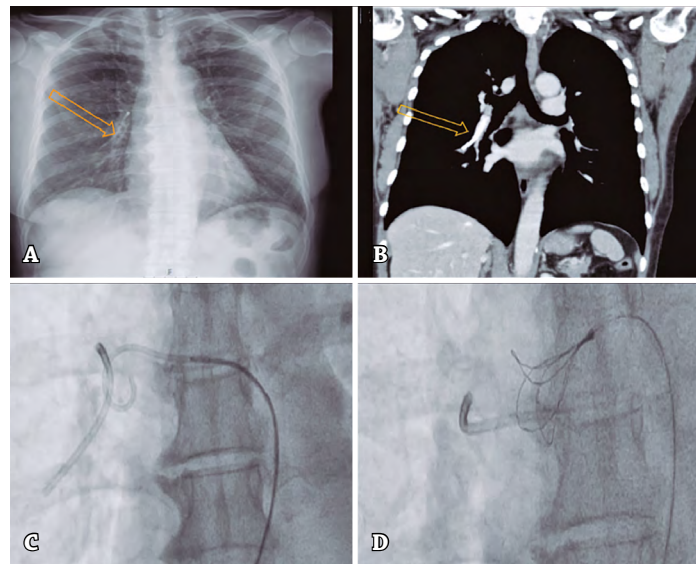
(A) Chest X-ray: intravascular portion of central venous catheter in the right pulmonary artery. (B) Thoracic computed tomography: intravascular portion of central venous catheter in the right pulmonary artery. (C) 5-F pigtail catheter grabbing one of the edges of the catheter fragment. (D) 6-F EN-Snare® catheter that collected catheter fragment.
